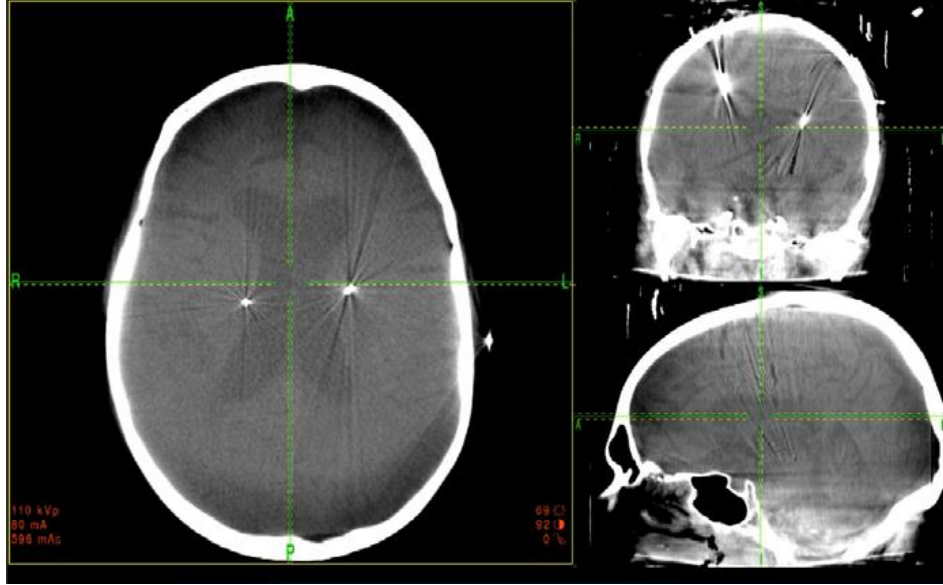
The metallic contacts of the DBS lead can be seen in the postoperative CT images by their electrode artifacts (Zhang 2013). These artifacts can be used to localize the final location of the contacts for use in later stimulation modeling.
